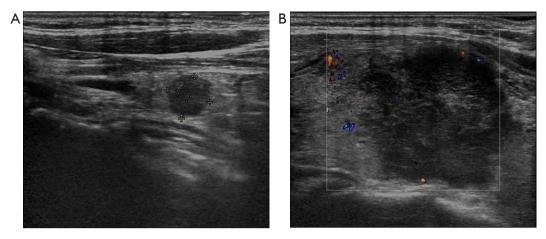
Ultrasound images of the patient's thyroid gland. (A,B) The right lobe of the thyroid was enlarged and the echogenicity of the gland was diffusely unevenly reduced. Hypoechoic area was seen in the right lobe, ranging from $3.45 \text{ cm} \times 2.50 \text{ cm}$, with unclear and irregular boundary, and blood flow signal was seen inside.
